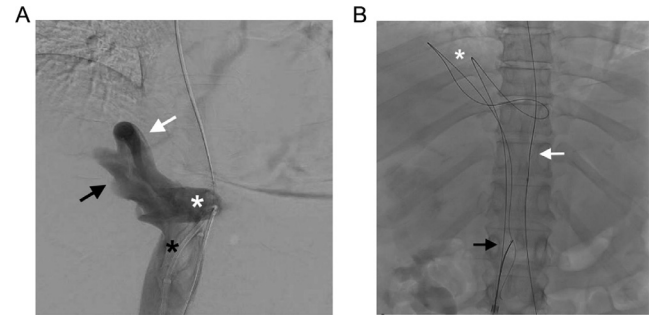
Ultrasound-guided percutaneous access into the sIVC (black arrow) and right atrium (asterisk) with a needle through the MHV (white arrow).
